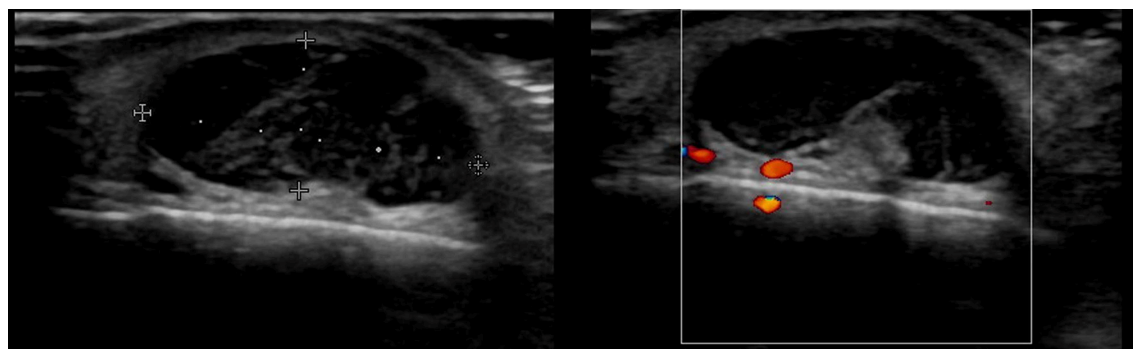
Ultrasound image of trichilemmal cyst.
